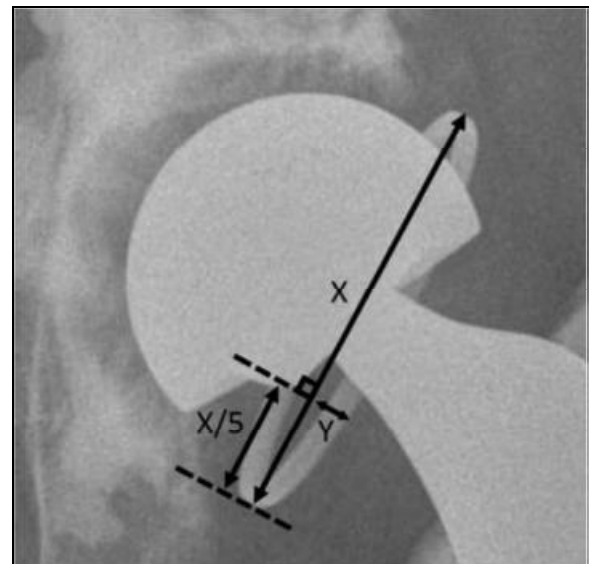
Radiograph with annotation showing measurements required for calculation of outer shell polyethylene acetabular anteversion angle. (Angle = $\text{Sin}^{-1}(Y/0.4X)$).
